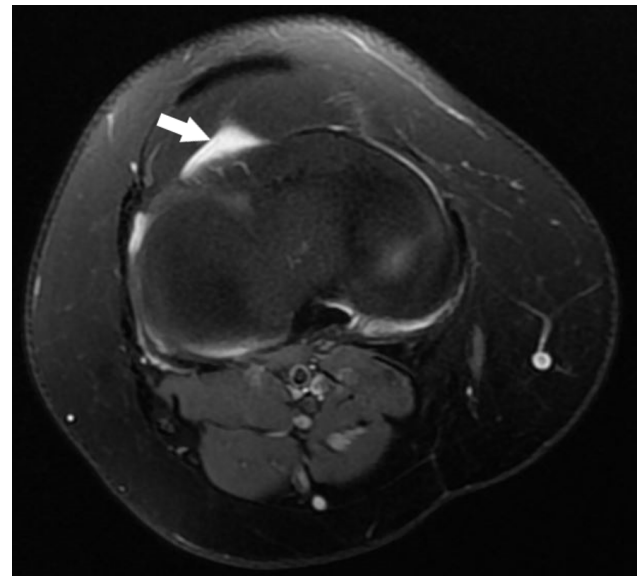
MR image (fat-suppressed axial PD) White arrow: Infrapatellar cyst
